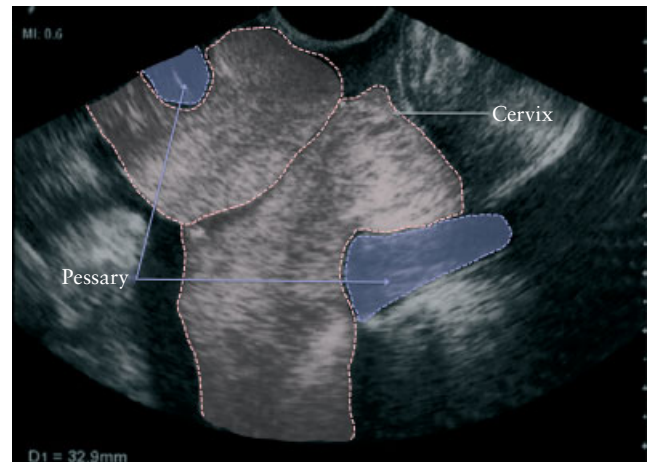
Visualization of cervical length in a woman with a cervical pessary using the new transvaginal sonographic technique.
